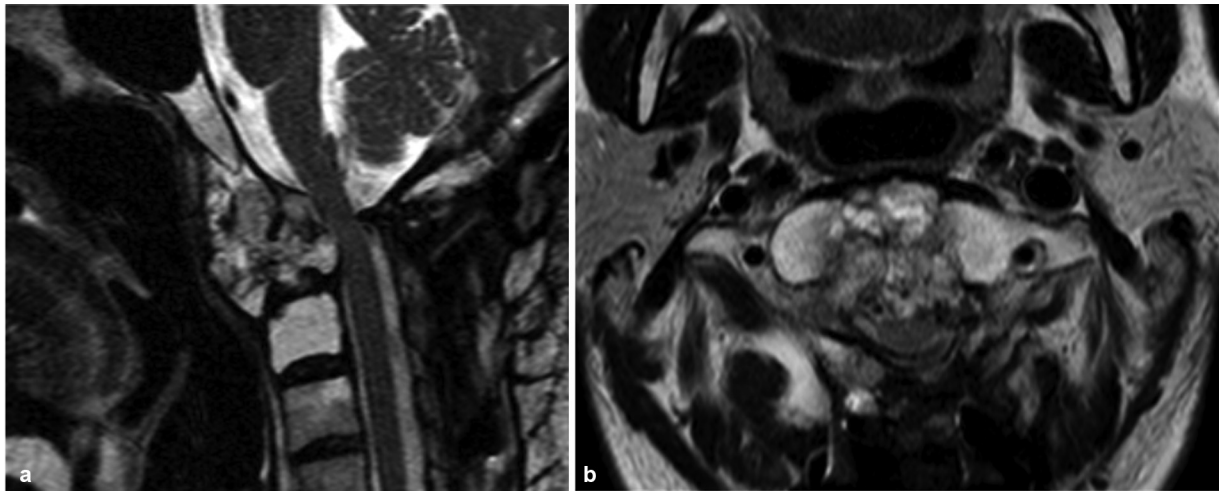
Preoperative magnetic resonance imaging (MRI) scans revealing gradual progression of the tumor. (a) Sagittal section. (b) Axial section.
